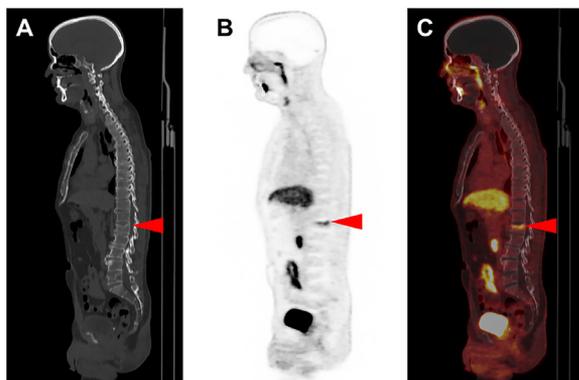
(A) Sagittal, attenuation-correction CT, (B) sagittal ^{18}F -DCFPyL PET and (C) sagittal ^{18}F -DCFPyL PET/CT images at midline in a 62-year-old man presenting for re-staging of prostate cancer. Note the linear radiotracer uptake at a superior endplate L1 compression fracture; the uptake lacks the focality that would be typical for a pathologic fracture.
